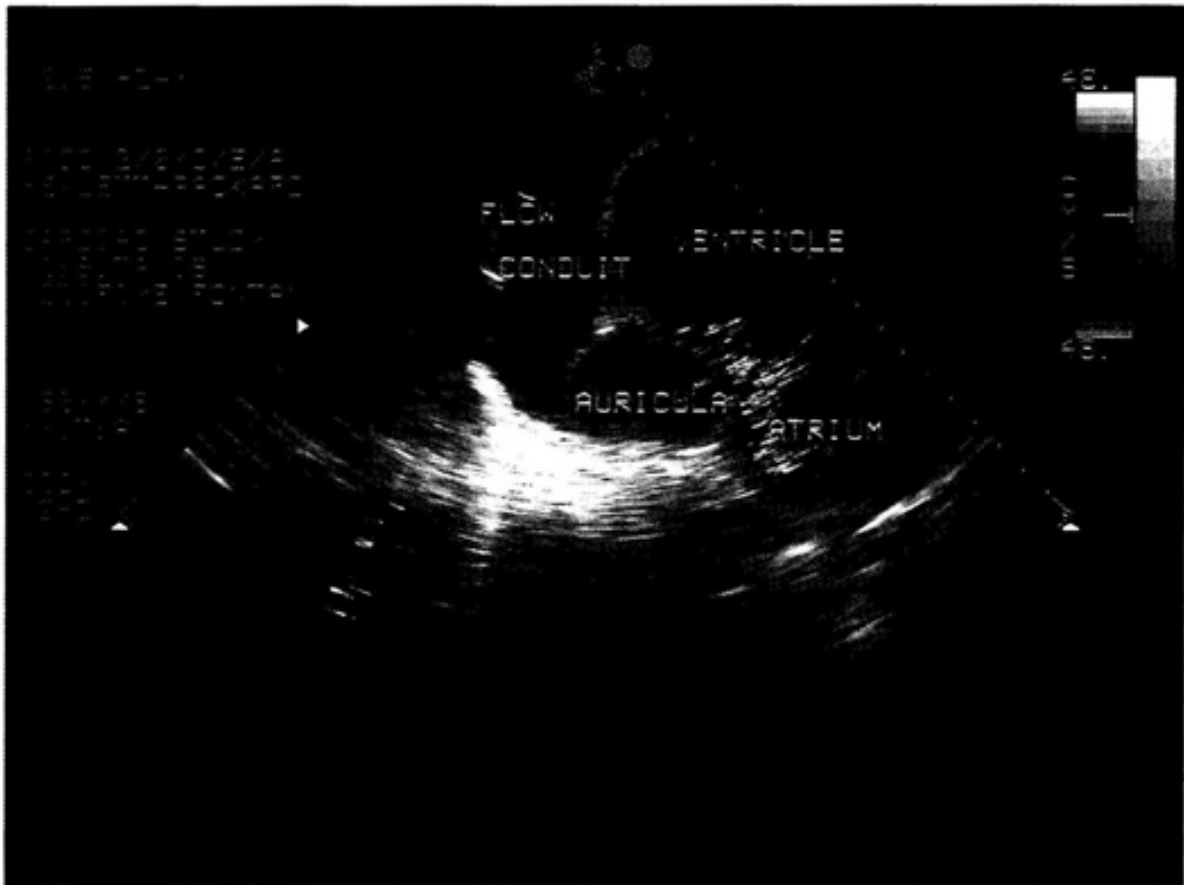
Postoperative control echocardiography
